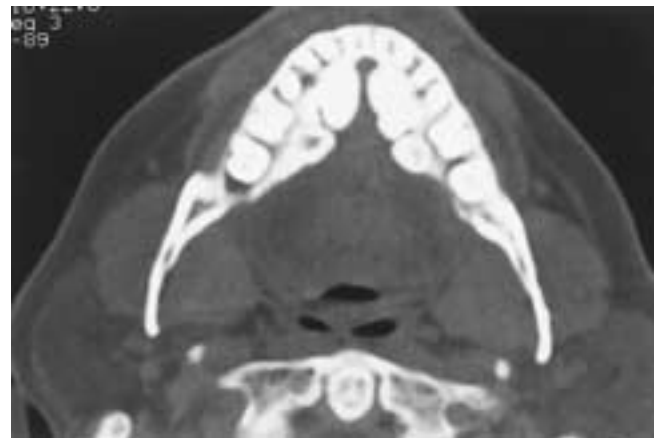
Torus mandibularis. Axial CT (bone window setting) through the mandible demonstrates bilateral bony exostosis of the lingual surface of the mandible.
